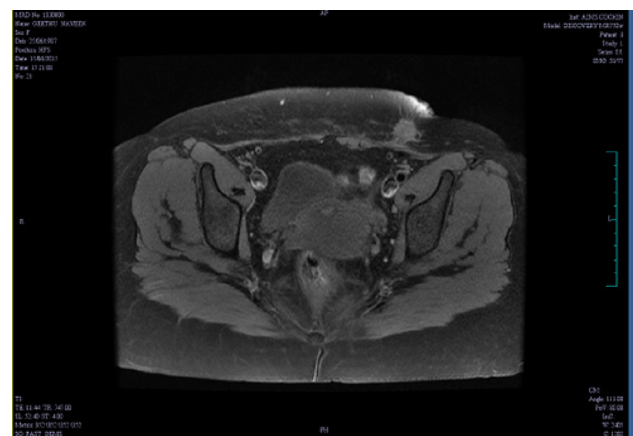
MRI of the lower abdomen T2 weighted image showing-scar endometriosis of It corner of the caesarean scar—hyperintense areas involving soft tissue, skin extending to rectus
